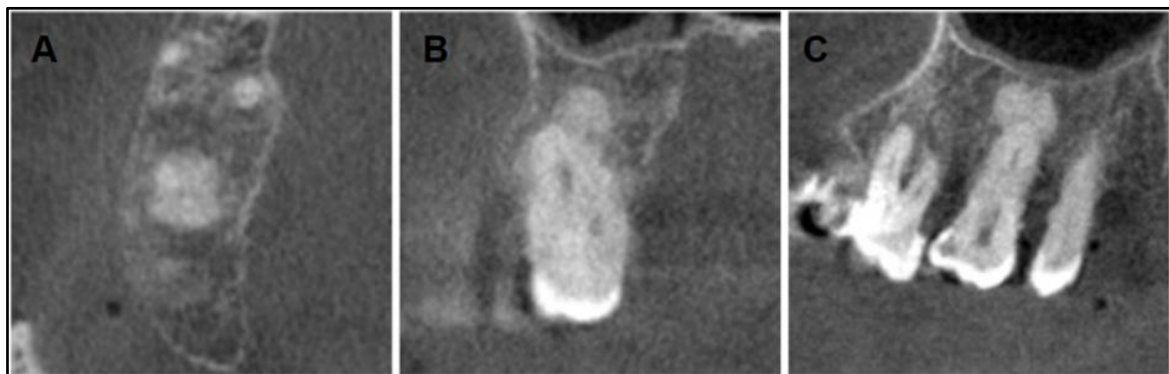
CBCT images; A: Axial B: Coronal C: Sagittal. CBCT was performed, revealing a well-defined radiopaque lesion with similar bone density and a narrow radiolucent border. Noteworthy, there were no signs of root resorption or cortical bone expansion/thinning.
